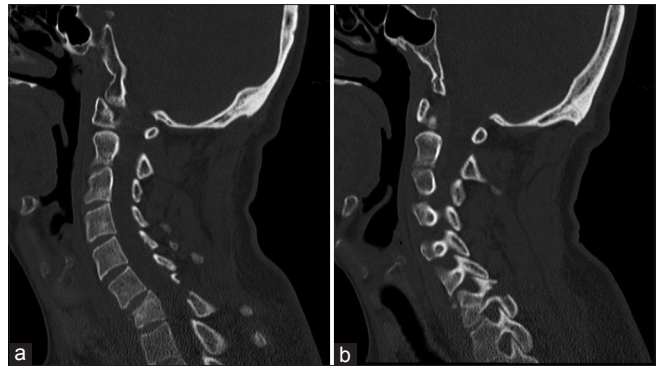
Sagittal cervical computed tomography-scan of the patient demonstrating flexion-distraction fracture of the C7 vertebrae. As demonstrated there is a compression fracture of the C7 vertebral body (a), and the fracture line has expanded through the posterior bony elements (b) resulting in fracture distraction injury
